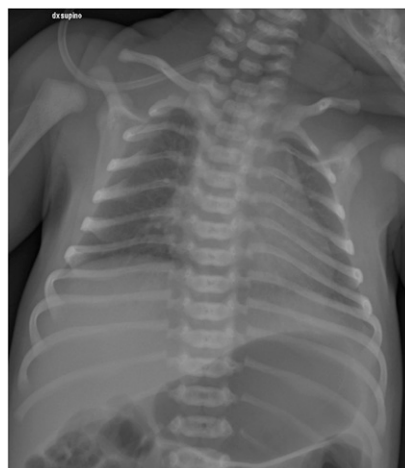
Chest radiograph of the newborn obtained on day of life 3 showing mild bilateral ground-glass opacities.
